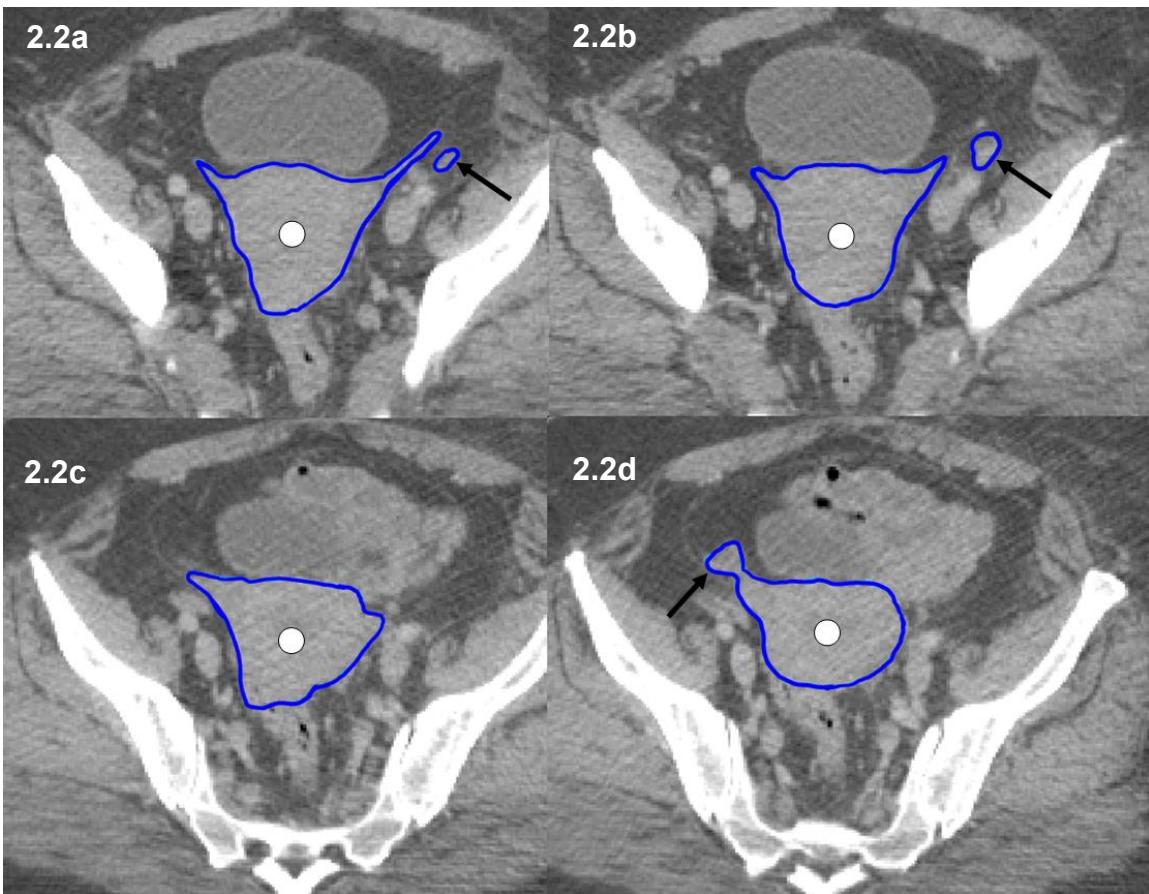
a-d: Sequential axial CT images with uterine corpus (circle) & ovaries (arrowed) outlined in continuity
